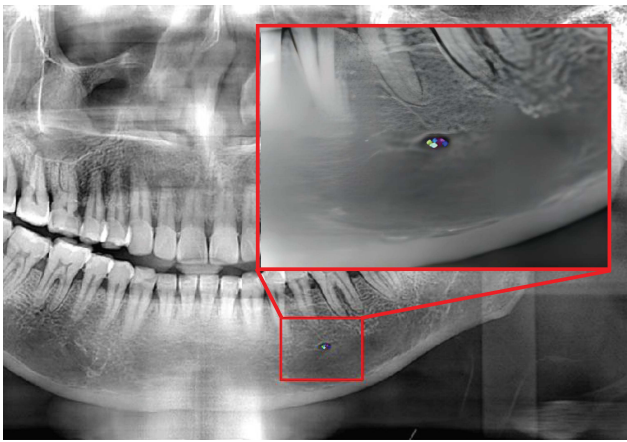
10 random points picked from the right mental foramen of the dental panoramic radiograph S29
